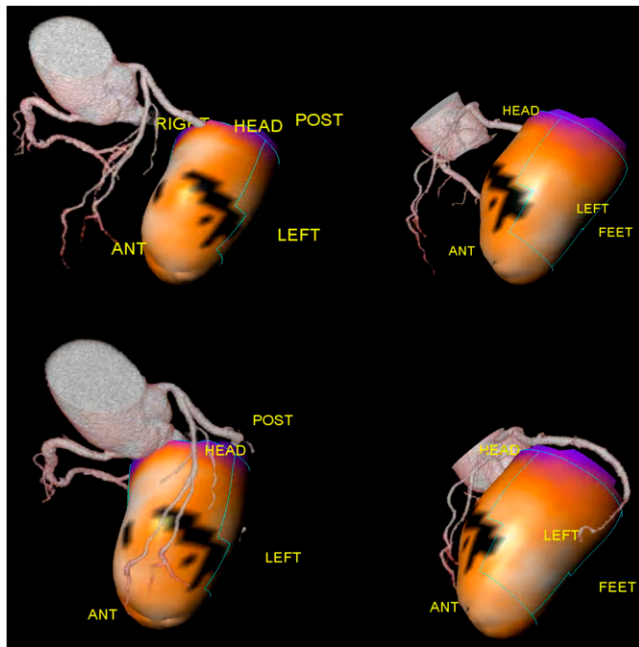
Automatic alignment of myocardial perfusion PET with 64-slice coronary CT angiography on hybrid PET/CT.
